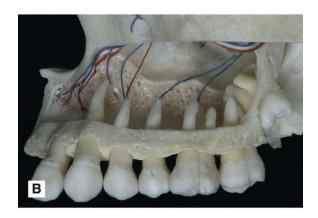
Photographs showing the three-dimensional anatomy of the premolar/molar region of a dried maxilla. (A) The external bone, (B) the teeth embedded in the bone and (C) a sagittal section through the mid-line. (D) Traditional two-dimensional radiographic image.
